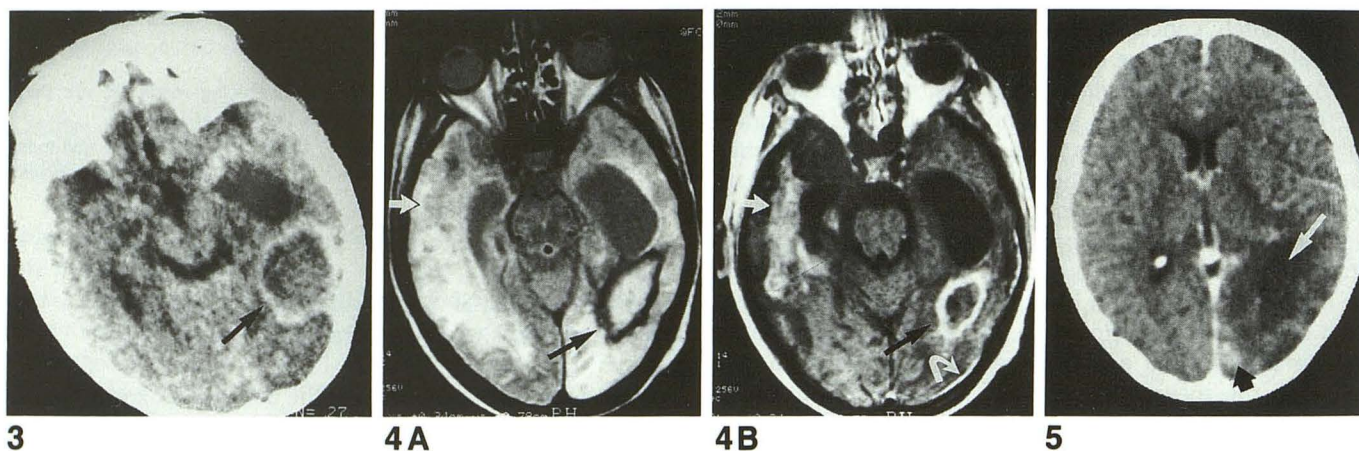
Nonenhanced CT scan obtained 1 month before stereotactic aspiration. Low-density lesion with hyperdense peripheral rim (arrow) in the left parietooccipital region (the right temporooccipital lesion is not visible on this section).
